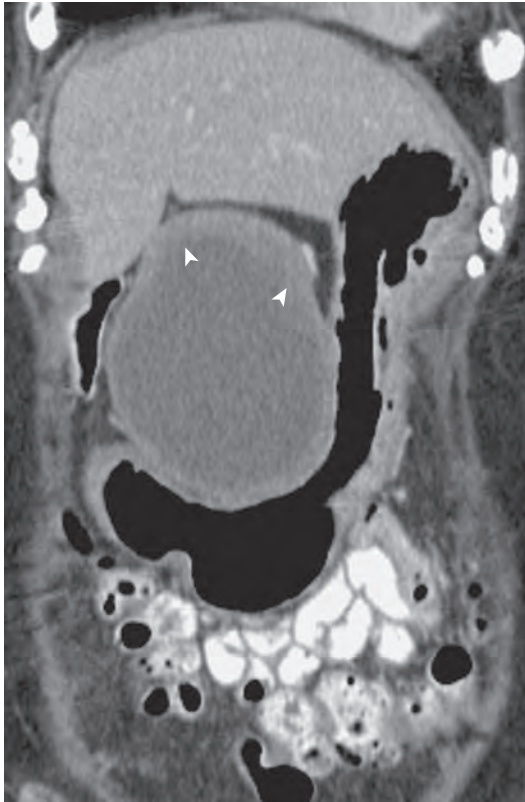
Malignant gastrointestinal stromal tumor on CT. Off-axis, coronal, volume-rendered MDCT scan shows a large mass arising from the lesser curvature of the stomach. The wall of the lesion (arrowheads) is irregularly thickened.
